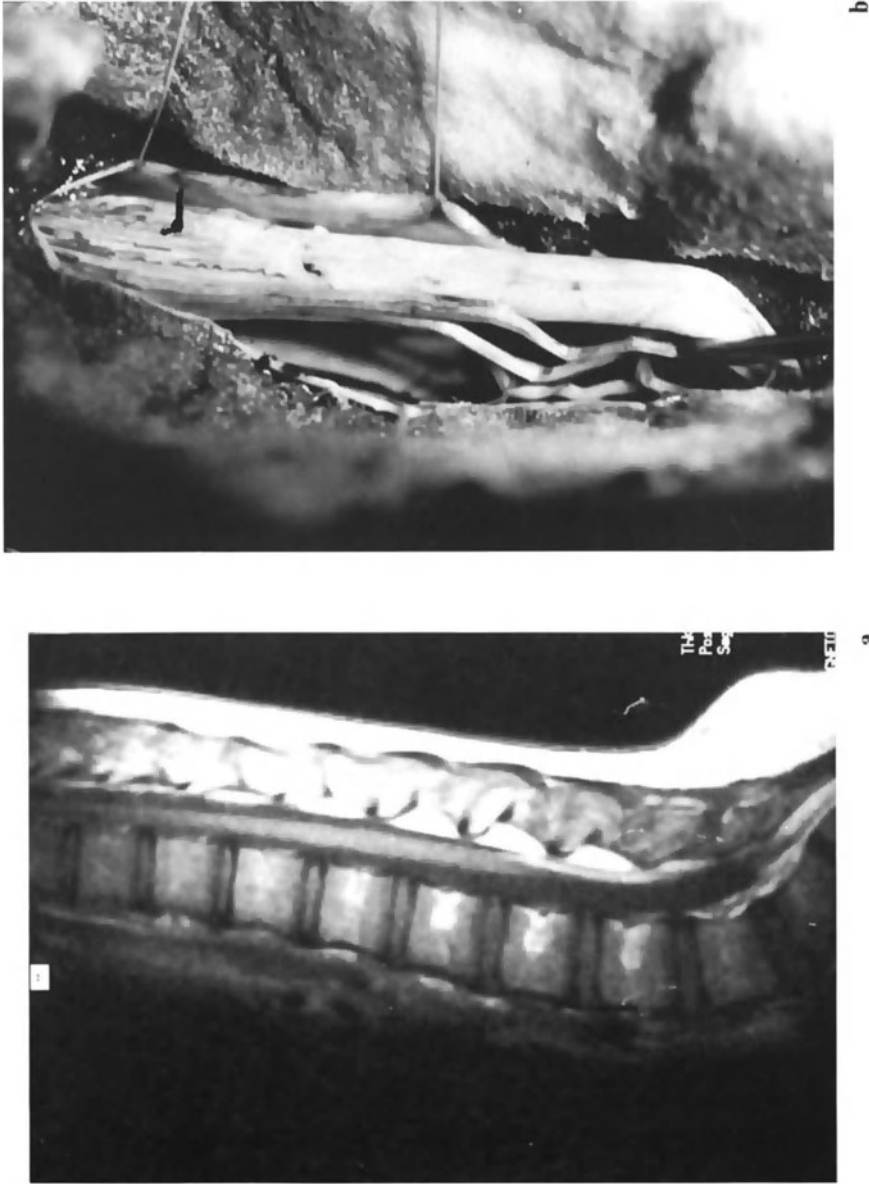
Fibrolipoma (lipoma of the filum). (a) MRI. The conus is at the L3 level and attached to an intradural lipoma. (b) Operative view. The conus continues with a thick and lipomatous filum fixed to the dura. The roots have a normal direction
